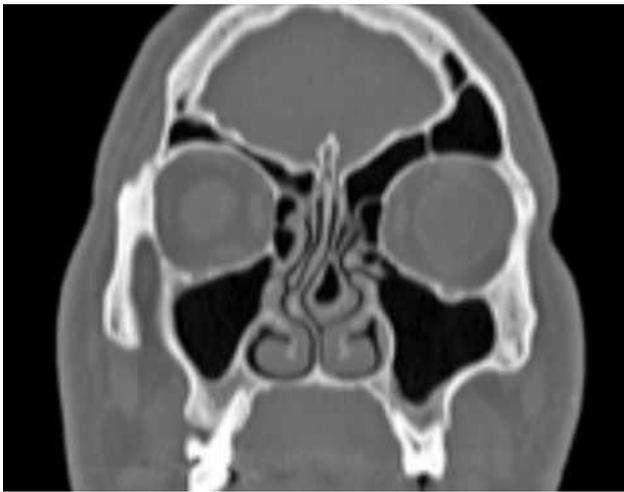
Paranasal computed tomography scan showing concha bullosa on the opposite side of septal deviation.
